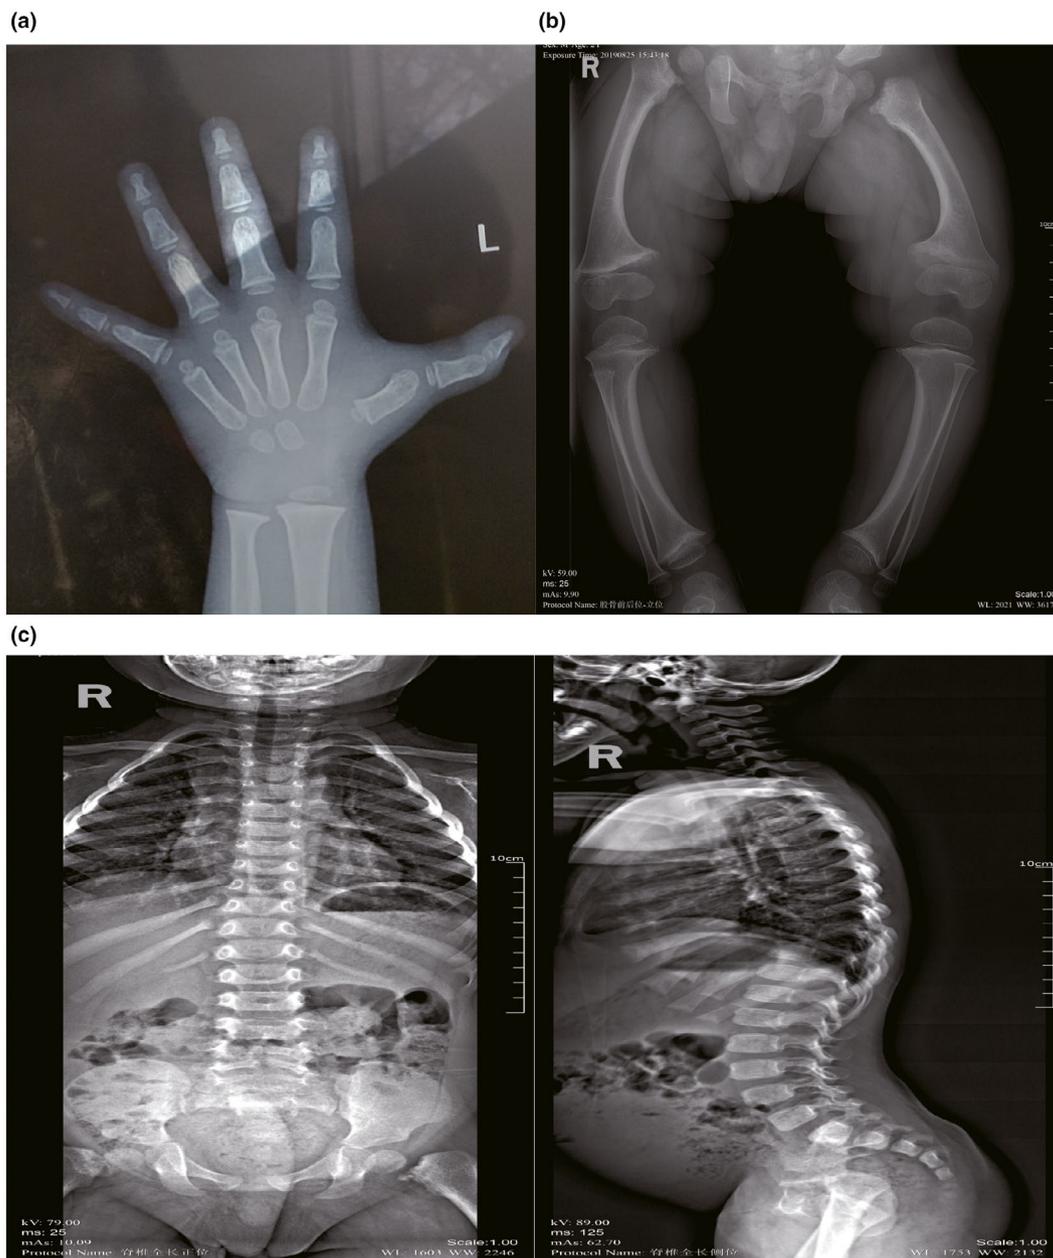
Radiographs of the patient at the first clinical examination. The results showed metaphyseal cupping of the proximal phalanges (a), coxa vara, metaphyseal widening, and irregularity of both femur and tibia (b) as well as mild dorsal scoliosis with a lumbosacral cleft in L4/5, S1 (c)
